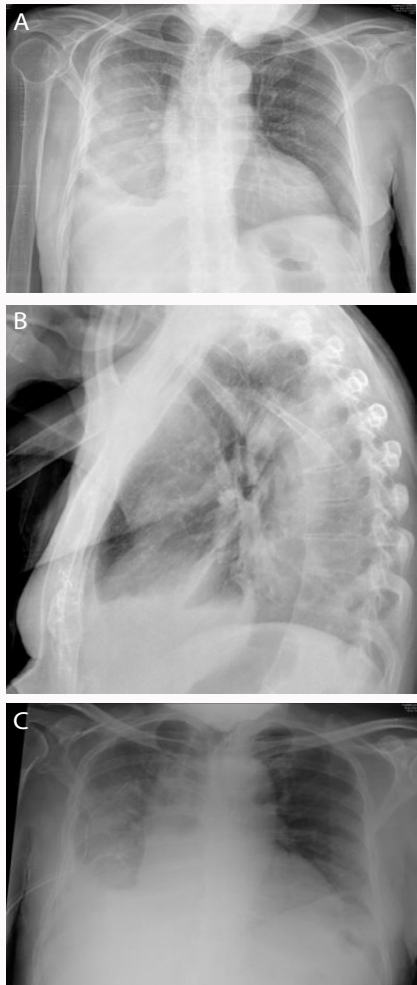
Chest x-ray shows opacity in the right hemithorax, pleural effusion that occupies almost the entire right lung.
